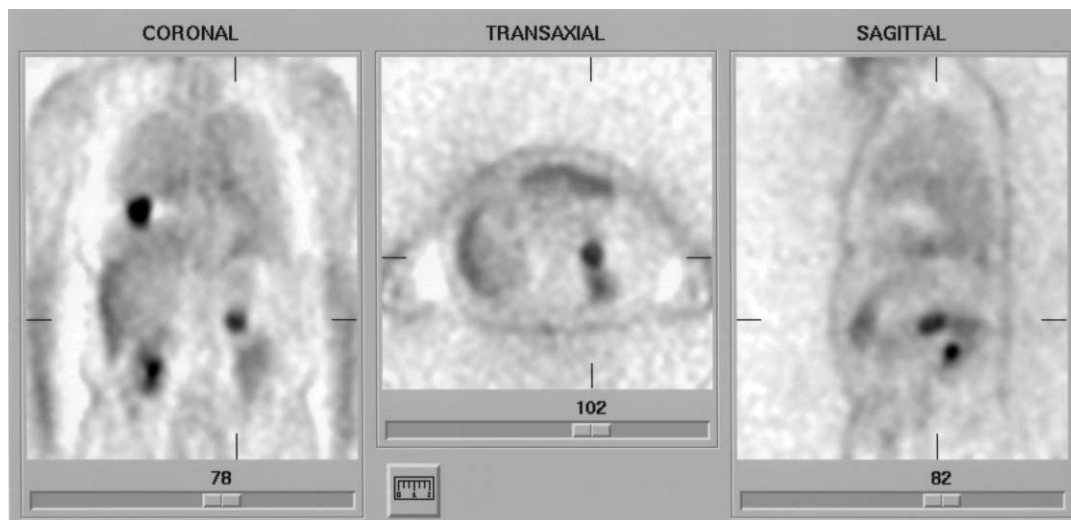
Fluorine-18-labelled deoxyglucose (FDG PET) scan in a patient with lung cancer and a left adrenal metastasis. The lung primary is also clearly visible. Image acquired with a partial ring dedicated PET system (ECAT ART). Note physiological urinary activity in the kidneys.
